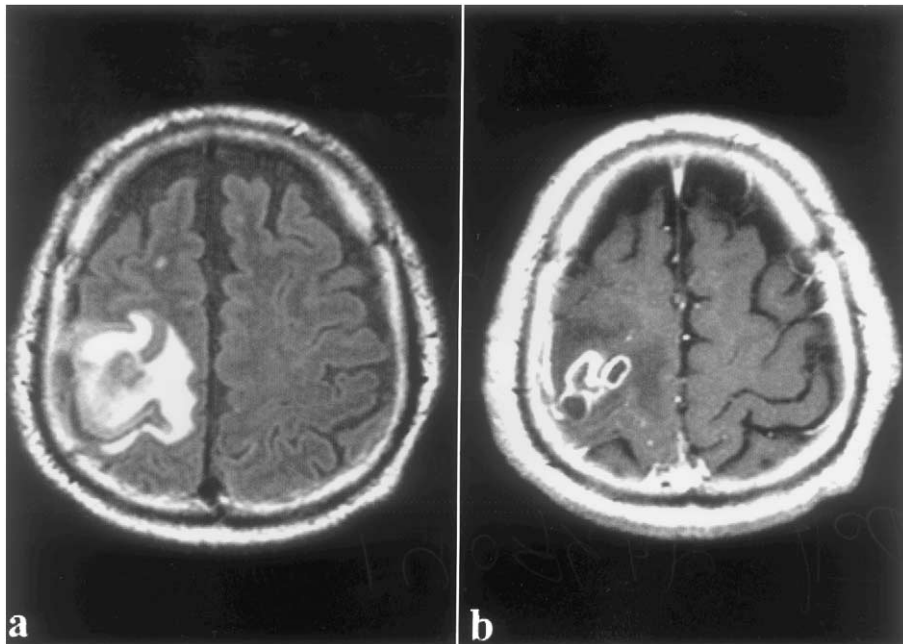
(a) FLAIR T2 sequence, sub-cortical matter hyperintensity due to edema. (b) SE T1 post gadolinium sequence, multiple areas of parenchymali 'Ring Like' enhancement.
